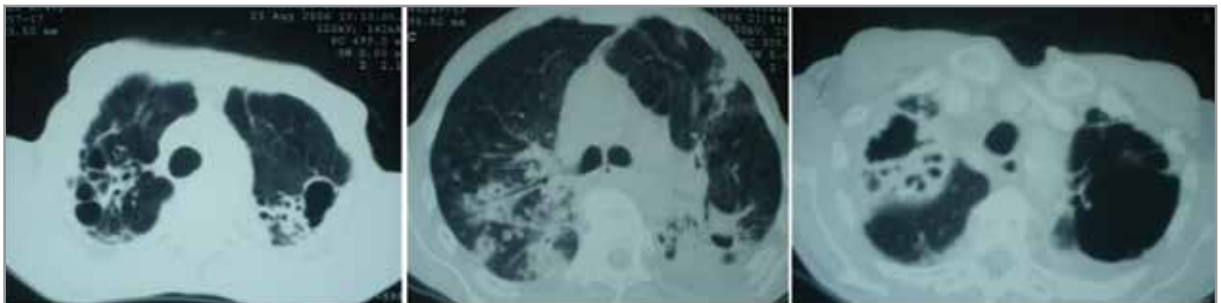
Thoracic computed tomography revealed bronchiectasis, air cyst.
